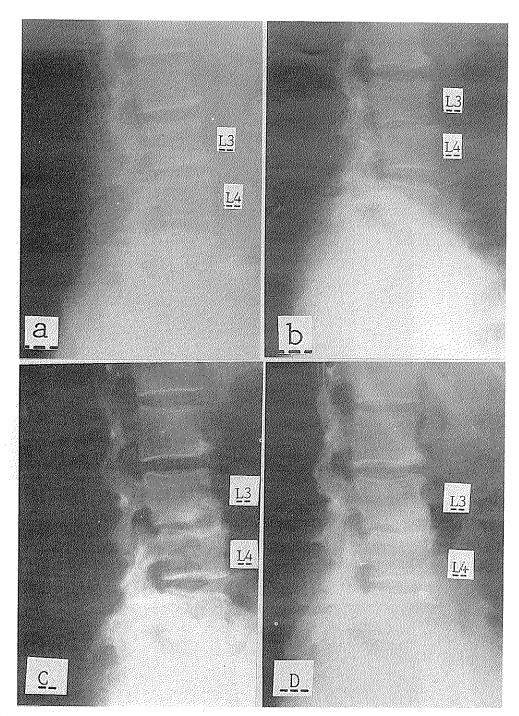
Plain X-ray films of L-S spine. (a): spur formation at L2, 3 and 4 vertebrae, and minimal retrolisthesis of L3 on L4. (b): marked narrowing of L3-L4 IVD, blurring of the cortex of the adjacent end plates, and progressive retrolisthesis of L3 on L4. (c) and (d): bone graft being taken (followed up 3 months and 7 months after operation, respectively.)
